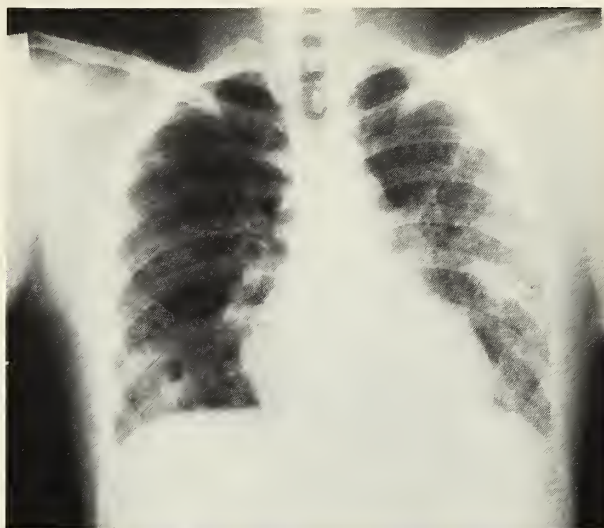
Pre-treatment chest x-ray showing cavitary lesions in the right middle lobe and in the left anterior superior lobe.
